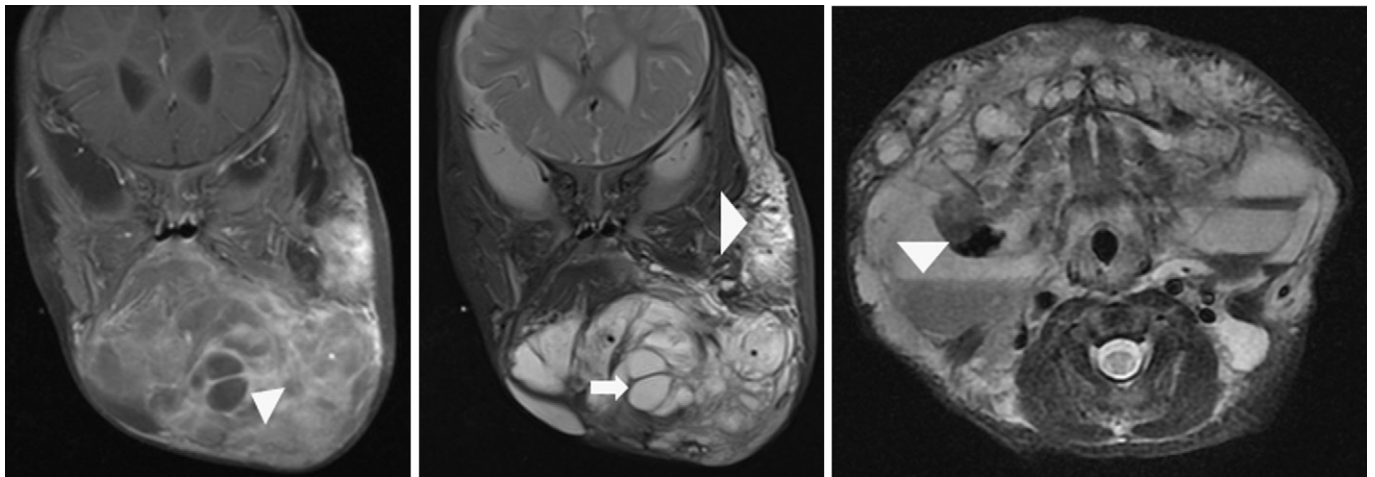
Magnetic resonance image of cervicofacial lymphatic malformation (LM). Coronal T1 image of an extensive cervicofacial LM (*left*), which shows contrast enhancement of septations and rims of cysts (*arrowhead*). Coronal T2 image (*middle*), which demonstrates macrocysts (*arrow*) and microcysts (*arrowhead*). Macrocystic component with a fluid-fluid level (*right, arrowheads*).
